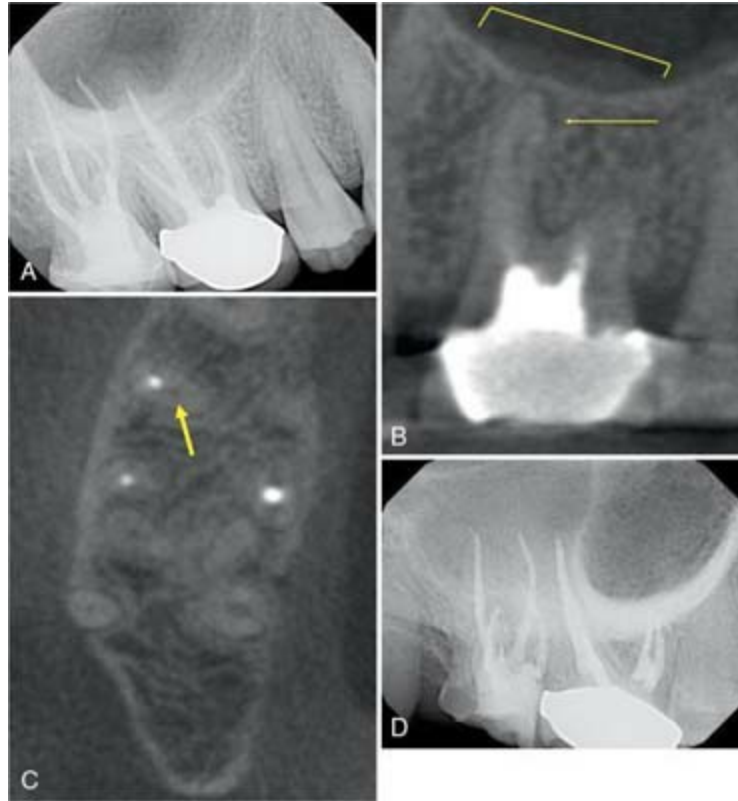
A, Preoperative radiograph of symptomatic tooth #3. B, Sagittal slice of tooth #3 showing periodontal ligament thickening and associated sinus mucosal thickening. C, Axial slice showing untreated MB2 canal (*arrow*). D, Treated case.
